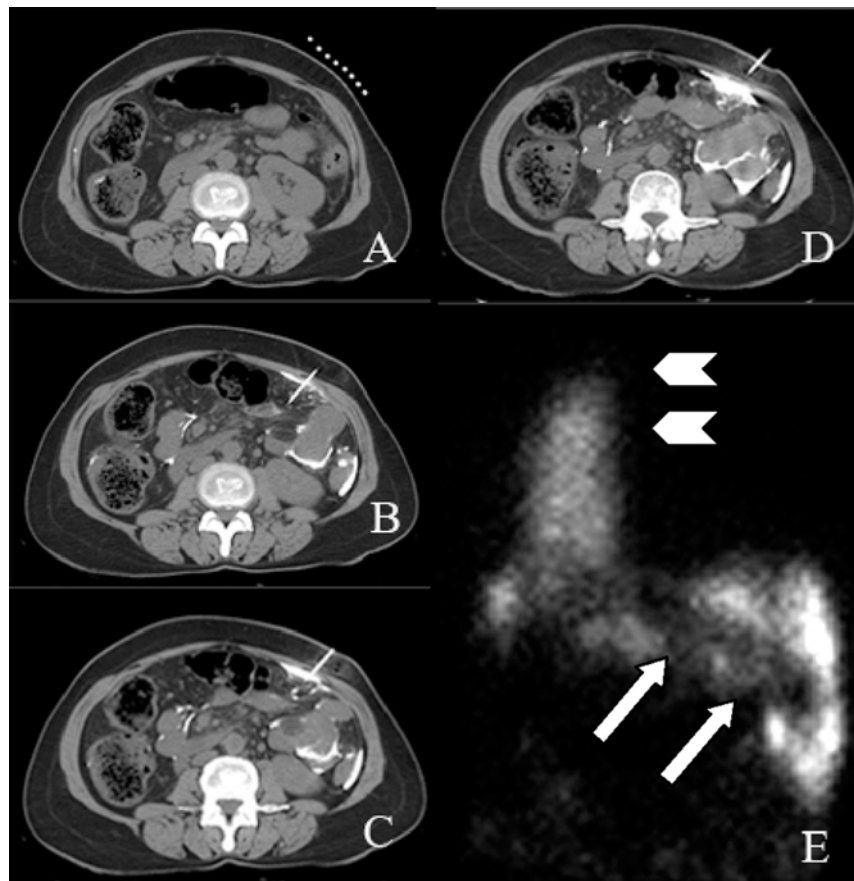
(A-D) CT scan images show CT guided abdominal tapping in a patient without ascites. Small amount of contrast media was injected to test position of the needle and (E) a ^{99m}Tc -MAA peritoneal scintigraphic image shows radiotracer activity in upper abdomen (arrows) and tracer migration into right sided pleural cavity (arrow heads), confirm condition of hepatic hydrothorax.
